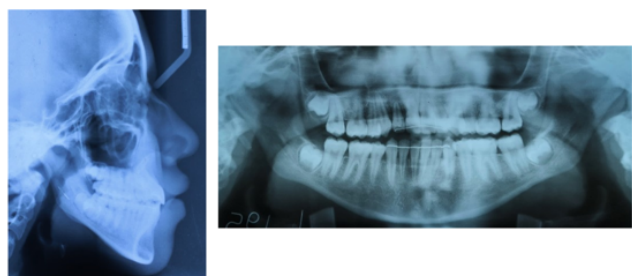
Post-treatment radiographs (lateral cephalogram & OPG)
